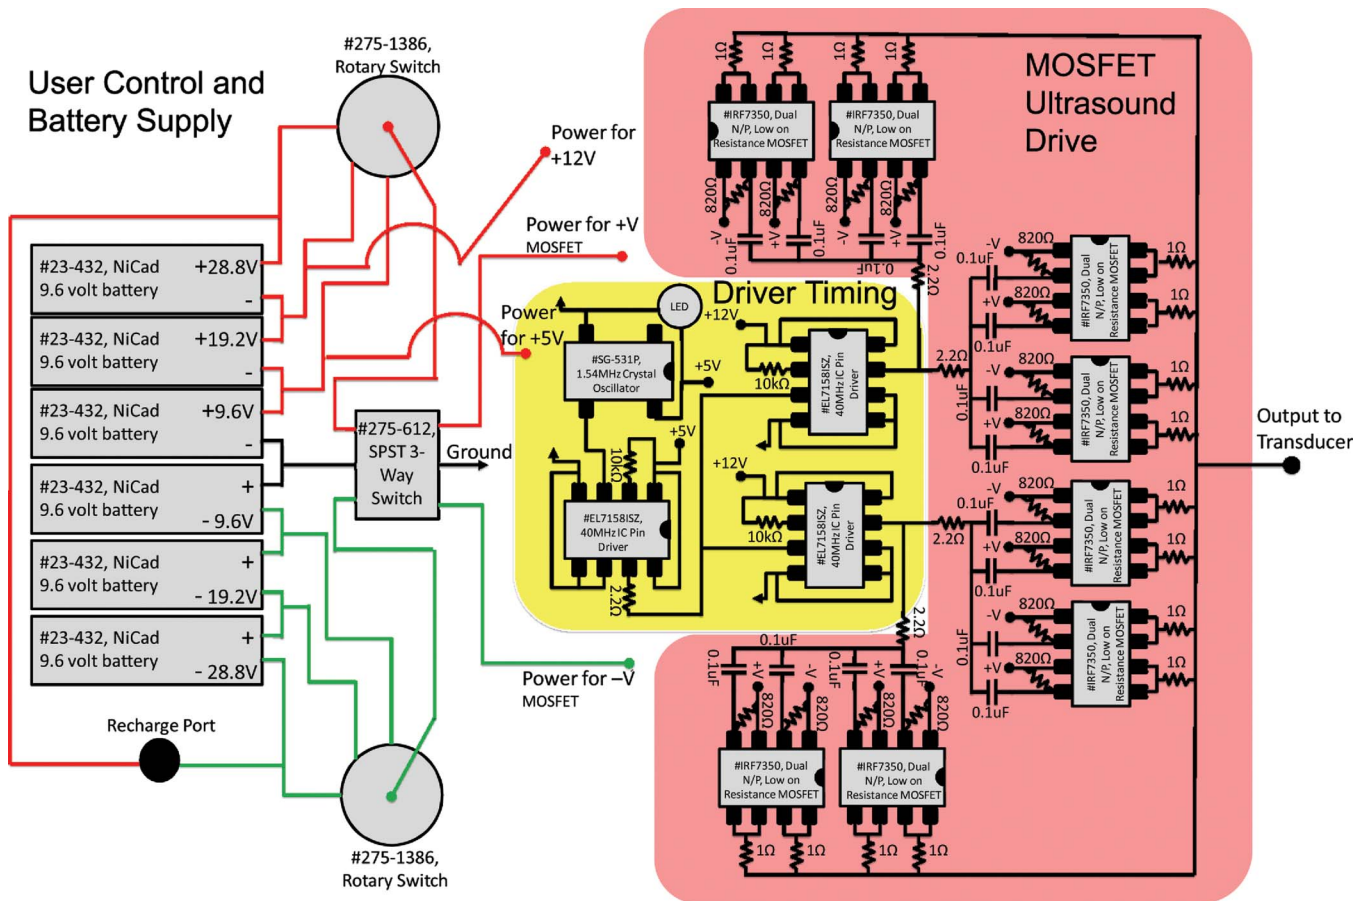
(Color online) Wire layout for portable ultrasound system.
